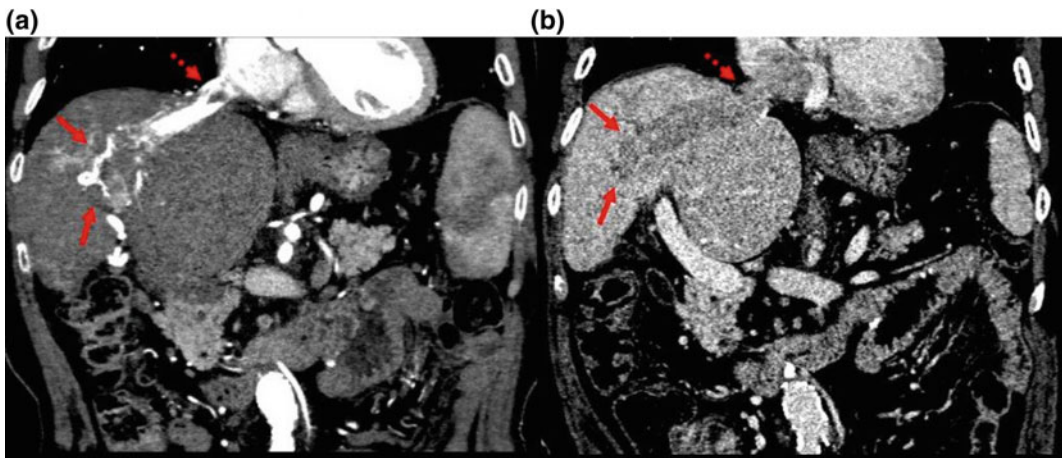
Coronal images from a triphasic CT scan showing an HCC (*arrows*) invading the hepatic vein and extending to the right atrium (*dashed arrow*). The
